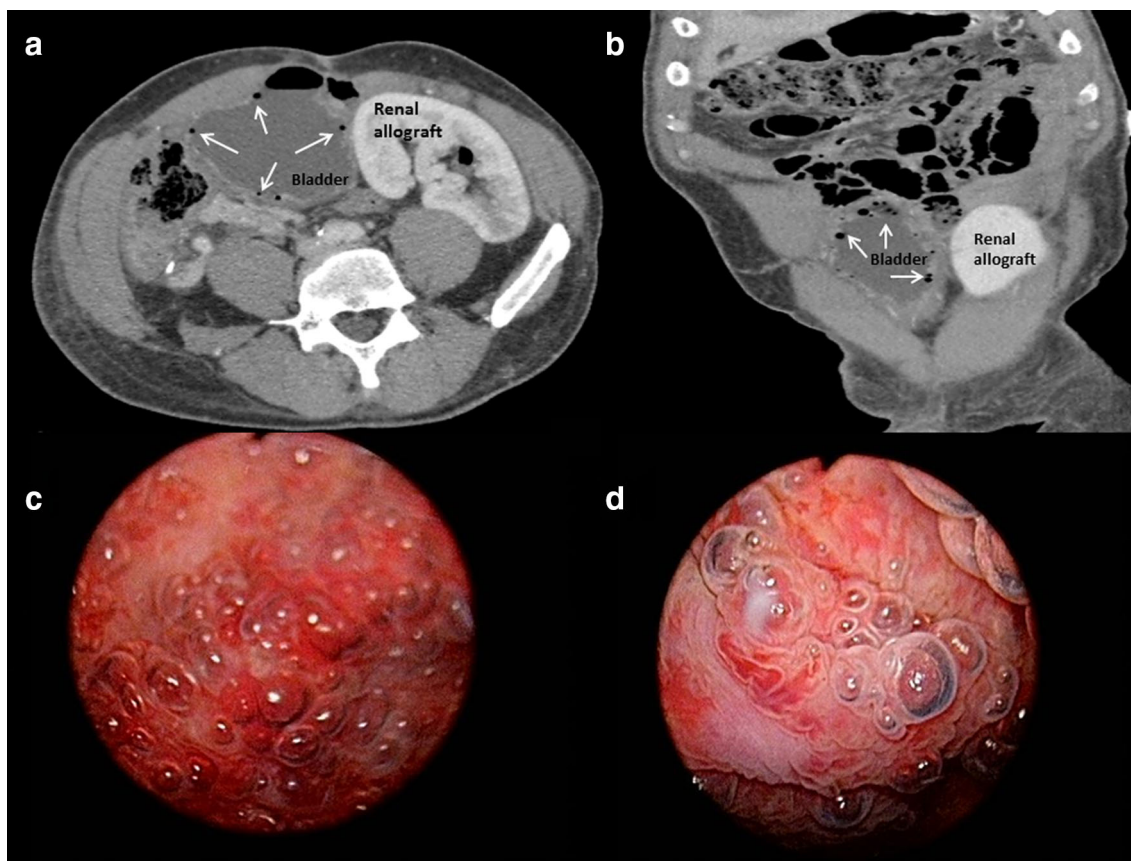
a, b CT scan of the abdomen showing distended urinary bladder with abnormal urothelial enhancement and multiple foci of air in the bladder wall (*arrows*). c, d Cystoscopy images showing diffuse submucosal emphysematous lesions with erythematous bladder mucosa
